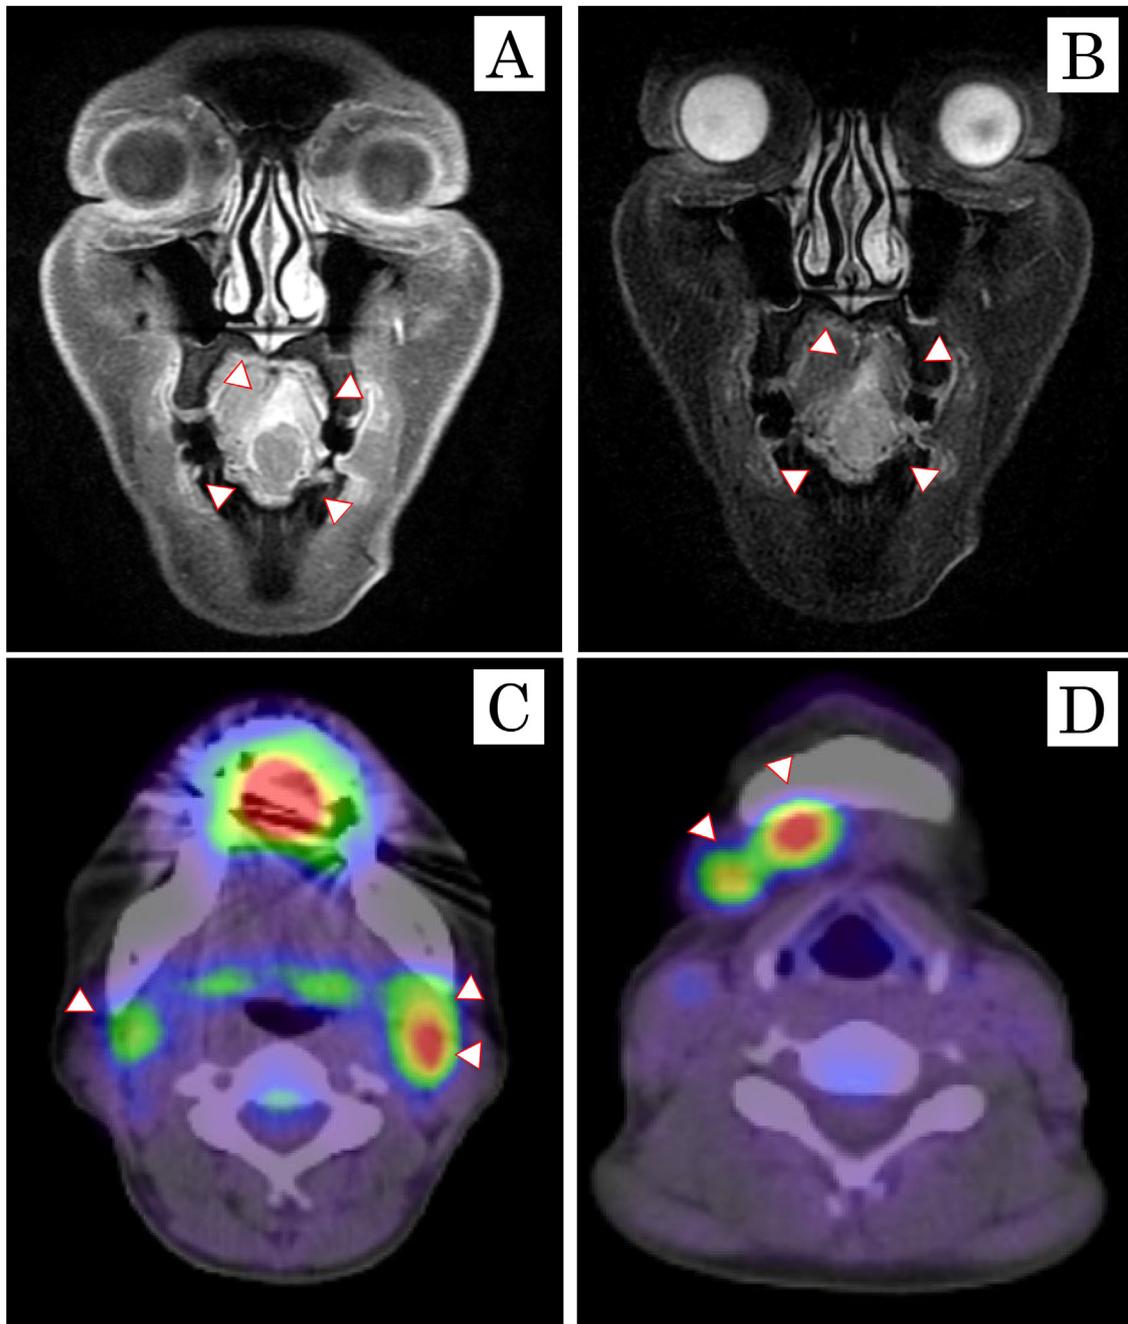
(A) Enhanced T1-weighted magnetic resonance imaging (MRI) revealed a $31 \times 26 \times 16$ mm, heterogeneous, moderate enhanced mass lesion with poorly defined margins on the left side of the tongue. (B) Enhanced T2-weighted MRI also revealed the same mass lesion with high-signal enhanced margins. (C) Positron emission tomography-computed tomography (PET-CT) revealed an accumulation of F-18 deoxyglucose in the right submental, submandibular and upper cervical lymph nodes and left submental lymph nodes with suspicious lymph node metastasis.
